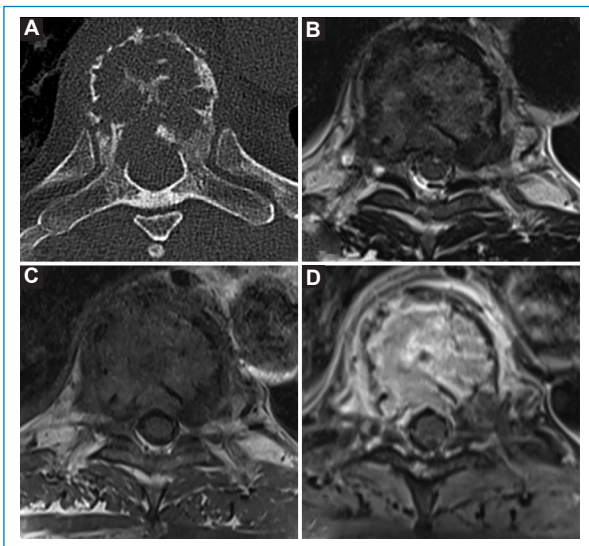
Axial CT of the dorsal column showing an osteolytic lesion with some dense bands that occupies a large part of the vertebral body, with *mini-brain* morphology, compatible with plasmacytoma (A), and MRI of the dorsal column of the same lesion, with mild T2 hypersignal and hypointense bands (B), isosignal compared to the muscle on T1 (C) and intense enhancement with intravenous contrast, with the perivertebral soft tissue component being more evident (D).
